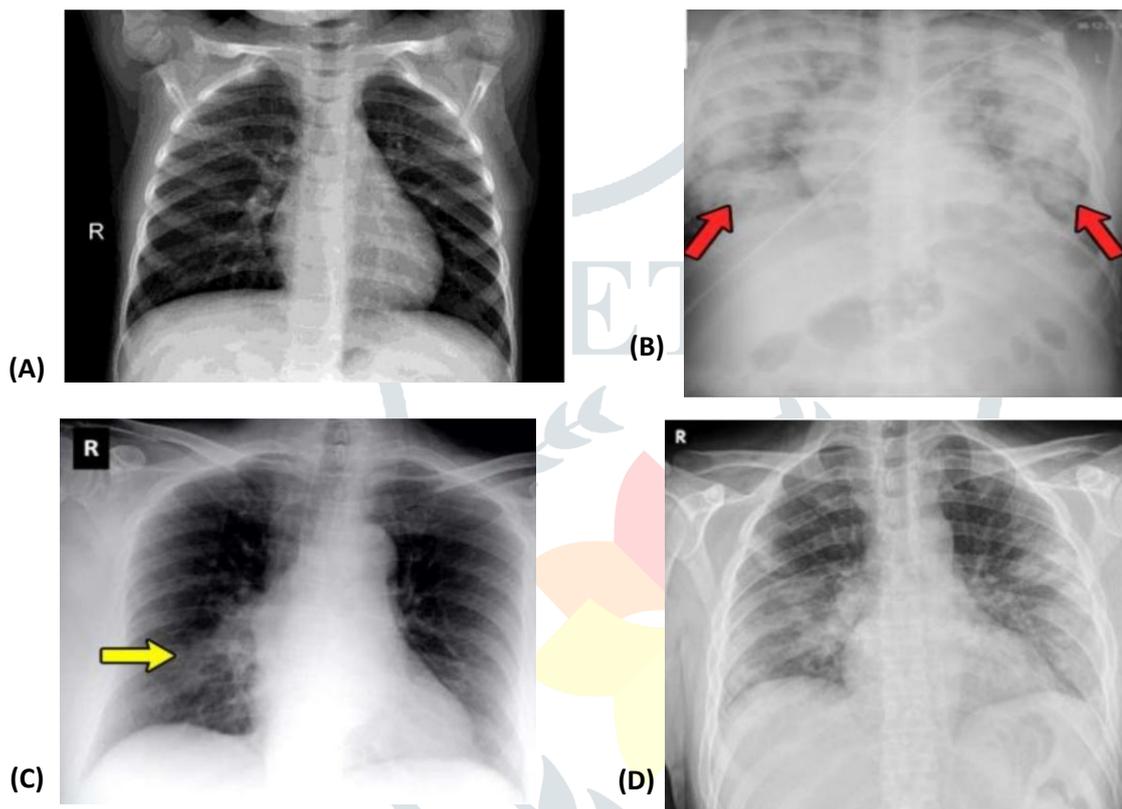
A. Normal chest x-ray B. Consolidation C. Ground glass opacity D. COVID-19 pneumonia
